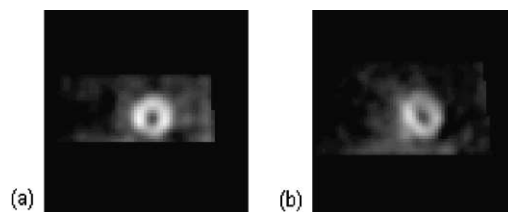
Perfusion on cardiac SPECT images: (a) Normal perfusion; (b) Abnormal perfusion.
